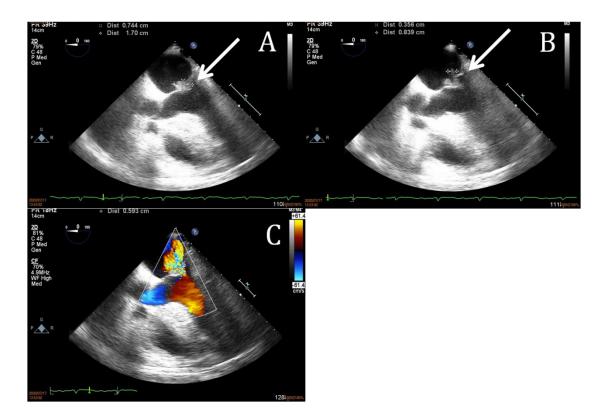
Transesophageal echocardiography images of patient.
